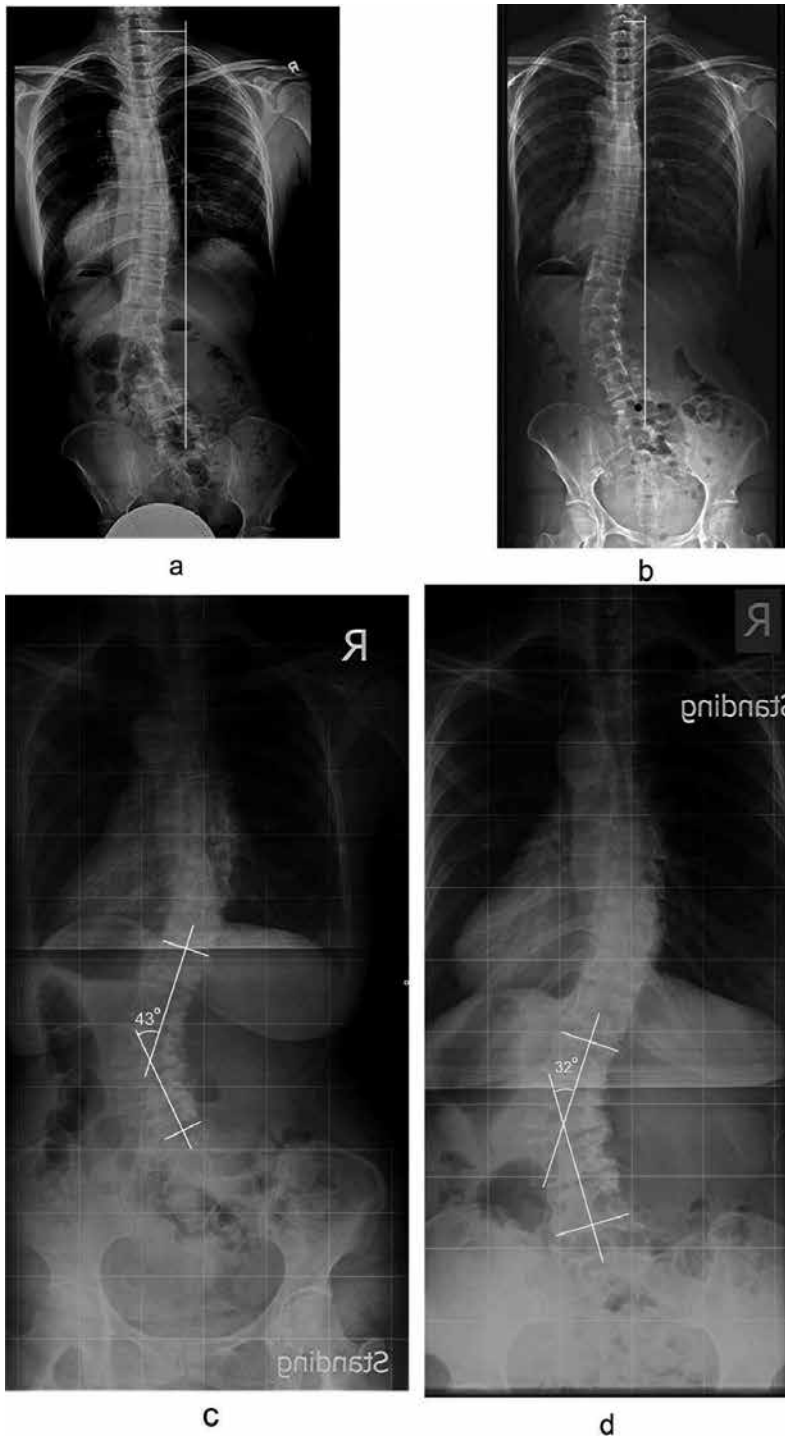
Posteroanterior full spine X-rays of a patient pre-intervention (a) and (b) post-intervention. It is noteworthy that her coronal balance improved. (c and d) The pre- and post-intervention X-rays of another patient, and the improvement of Cobb angle was noted.
